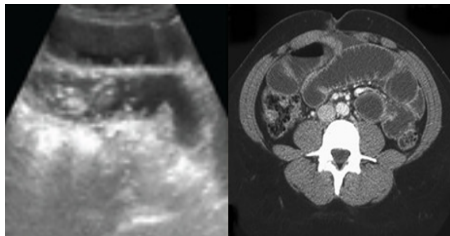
Small bowel distension, with some degree of wall thickening and fluid distended loops. On CT there is a "whirling" of the mesentery and vascular engorgement.
